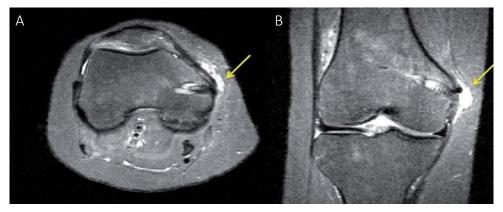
Axial (A) and frontal MRI (B) showing swelling and femoral screw migration after MPFL reconstruction (yellow arrows).
